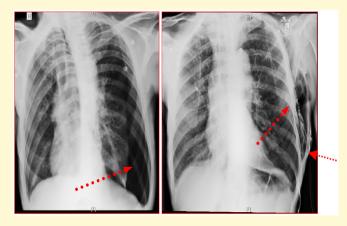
(A)Frontal Chest Radiograph showing left sided spontaneous tension pneumothorax. (B) the side holes of ICDT are in Subcutaneous plane leading to subcutaneous emphysema.
